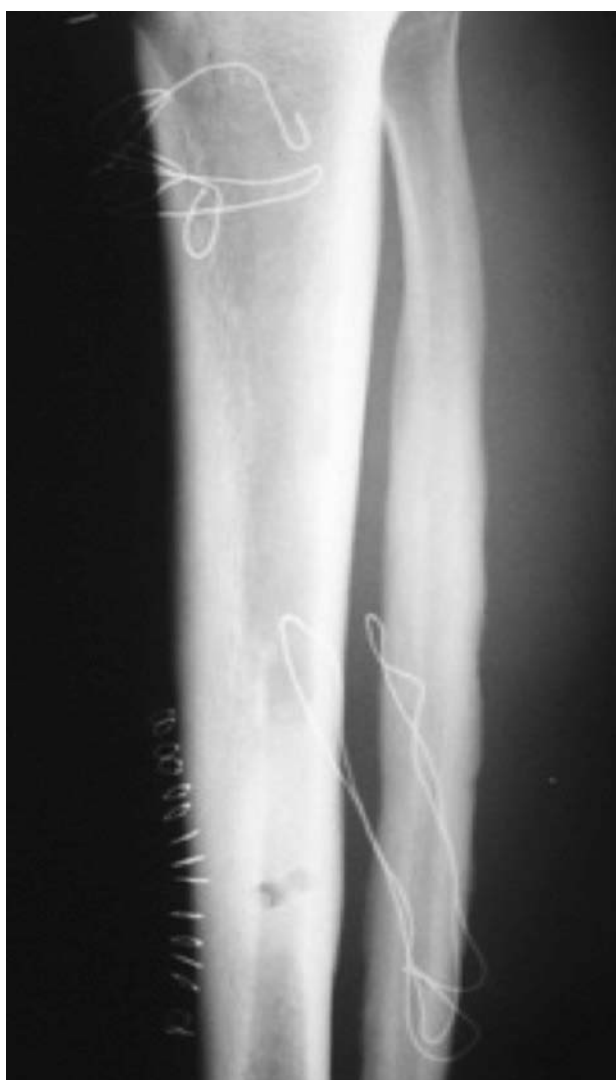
X-ray follow-up after reaming the intramedullary canal of the affected tibia.
